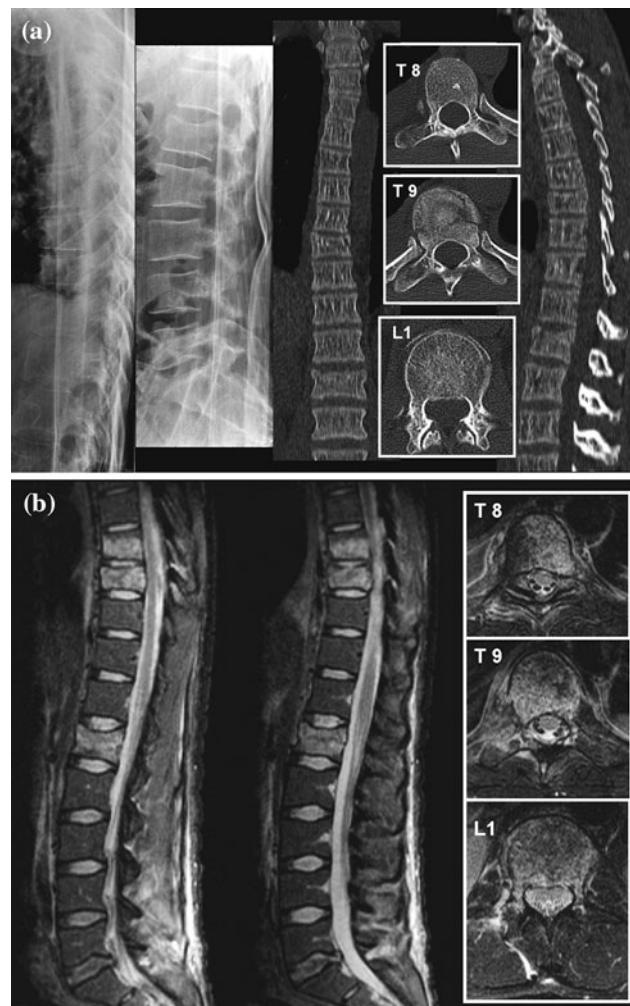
a Case 27. Male who suffered a traffic accident. Initial X-rays show an L1 fracture and a possible T8 fracture. CT scan demonstrates a T9 fracture classified as AO type A1, and an L1 incomplete burst fracture classified as AO type A3, there is no suspicion of a T8 fracture. b The same case analyzed with MRI, T2-w STIR sagittal and T2-w FS axial images. An occult injury is detected in T8 with an inferior plate disruption (AO type A1). T9 fracture is upgraded to an AO type B2 because of interspinous ligament rupture. L1 shows an intact PLC, remaining as an AO type A3
